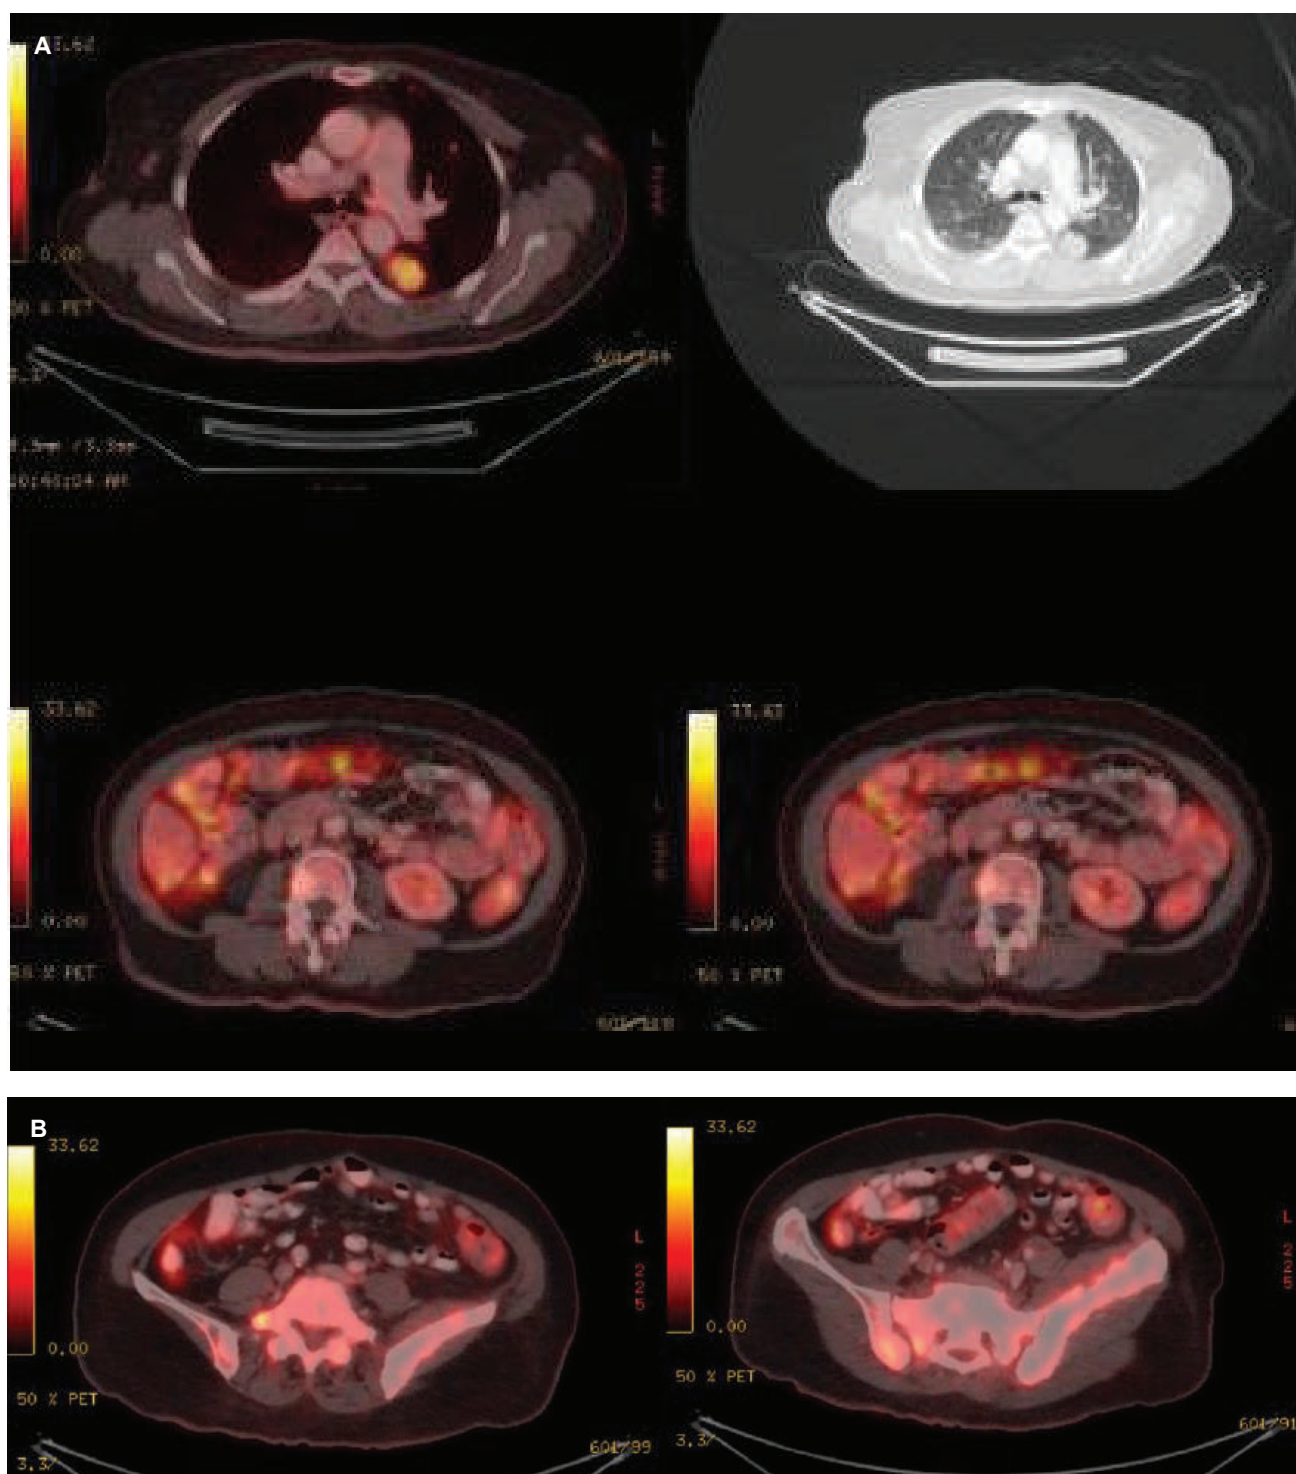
(A) ^{18}F -FDG PET/CT revealed that there was a hypermetabolic lung mass (SUV max 7.3) measuring 2.7x2.1x3.7cm at left lower lobe of the lung corresponded to the hypodense lesion at CT scan. There was a new hypermetabolic activity in patchy areas of lucency and sclerosis of the right side of sacral bone, right ilium, bodies of L3-L5 and right lamina of L5. (B) ^{18}F -FDG PET/CT revealed that there was diffuse sclerosis of the left hemipelvis (ilium, ischium and pubic bone) with minimal metabolic activity in keeping with PDB.
